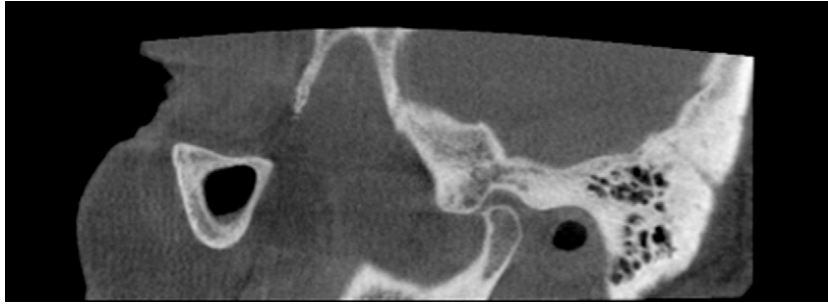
CBCT of beaking of anterior aspect of condyle—remodeling or small osteophyte? (female, 61 years).
